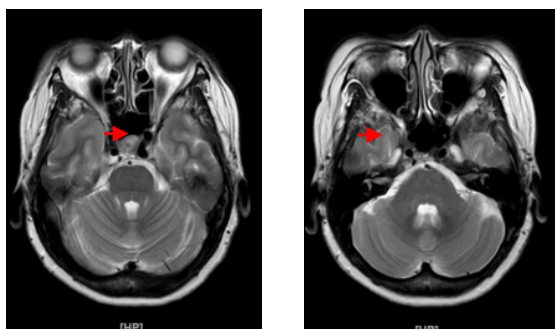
Magnetic Resonance Imaging (MRI) with contrast in T2 sequences revealed a dilated right dorello's canal with a non-enhanced cystic lesion on the right side of the superoposterior cavernous sinus (0,8x0,5x0,5 cm).
